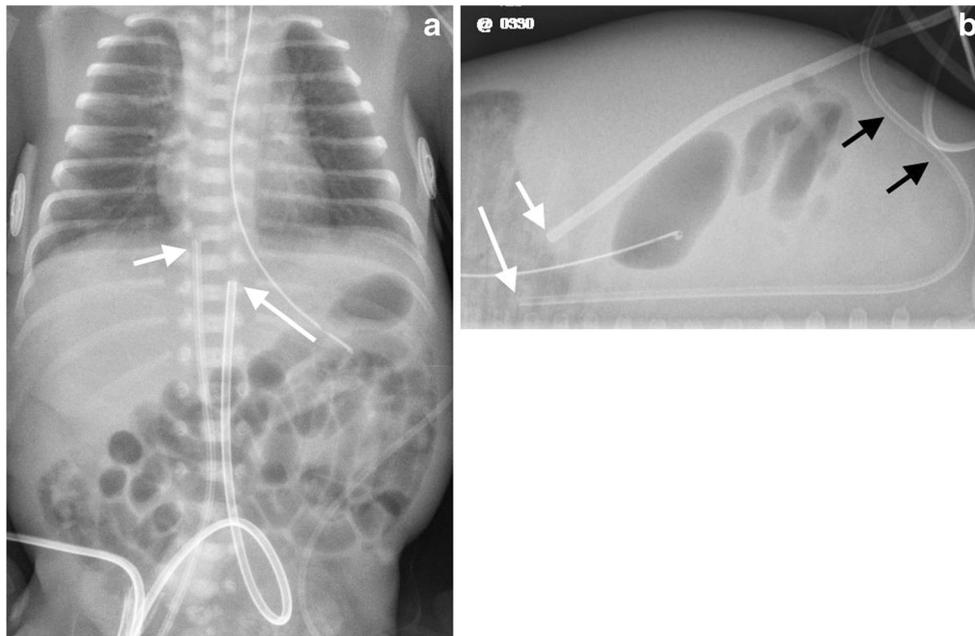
Correct umbilical catheter position in a 3-day-old boy. a Anteroposterior radiograph shows the umbilical venous catheter tip (*short arrow*) correctly sited. An umbilical venous catheter follows the umbilical vein and traverses the central part of the left portal vein (Rex segment) into the ductus venosus to reach the inferior vena cava. The line tip should ideally be sited at the cavo-atrial junction or upper inferior vena cava but outside the heart, which usually corresponds the level of the vertebral bodies T8–T9 or the level of the diaphragm. The umbilical arterial catheter tip (*long arrow*) is positioned high, well above the level
